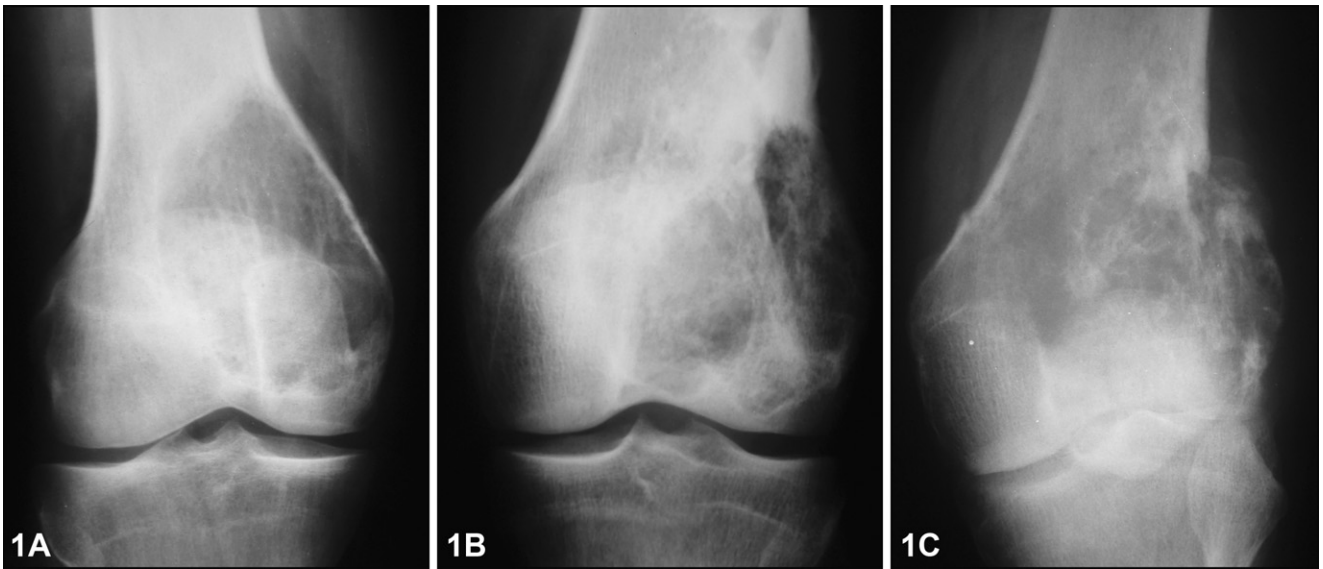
Case 1: AP radiographs. (A) Aneurysmal Bone Cyst, January 1985: well limited lytic lesion. (B) September 1991: heterogeneous filling of the lesion by the graft. (C) December 1991. Cortical destruction and soft tissue involvement by the osteosarcoma.
